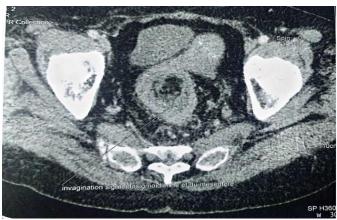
(A, B): Axial CT scan images showing the sigmoid-to-sigmoid intussusception with diffuse wall thickening
